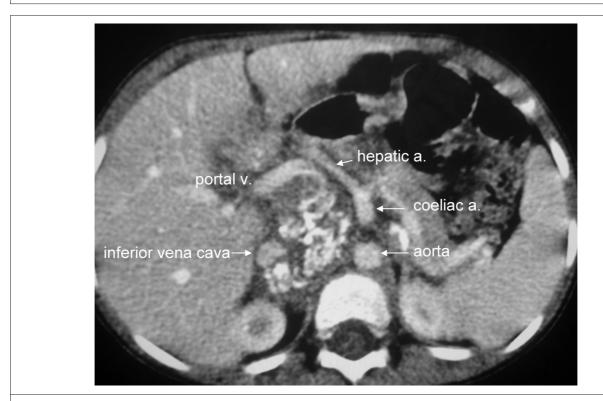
Post-chemotherapy CT scan showing tumour shrinkage.
